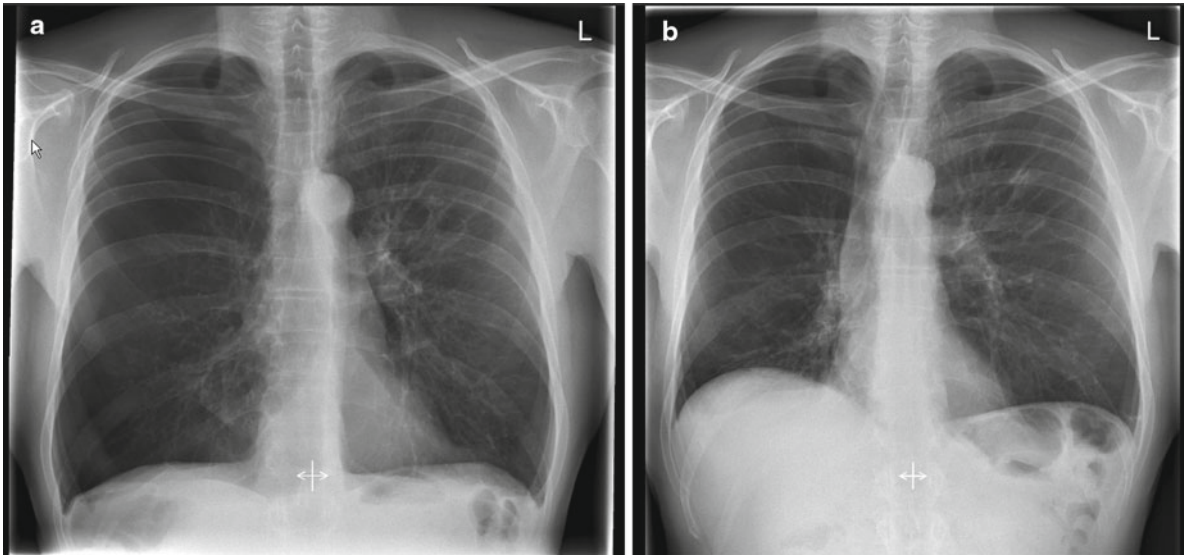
Chest X-ray of the patient shown in Fig. 49.2. The X-ray on the *left* shows the hyperinflated lungs and depressed diaphragm. The X-ray on the *right* demonstrates right upper lobe collapse, volume reduction, and a more normal diaphragm configuration
